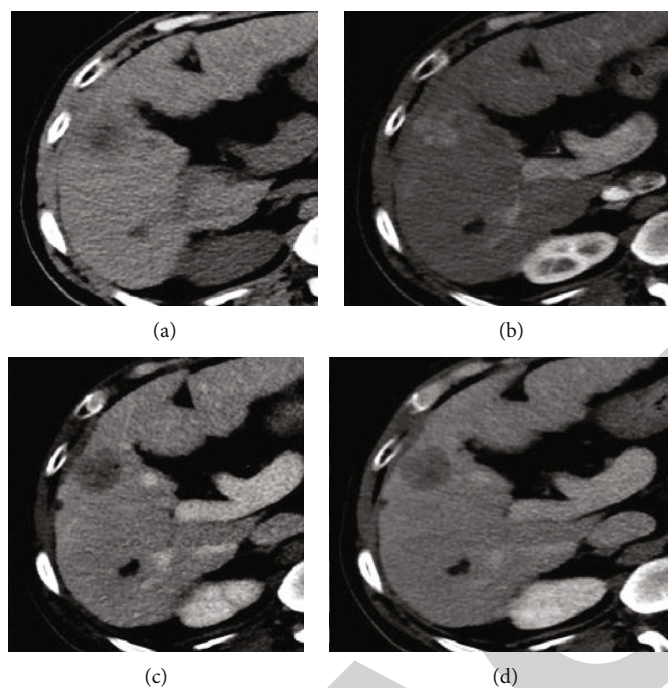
CT image of hepatocellular carcinoma. (a: plain scan period; b: arterial phase; c: portal venous phase; d: delayed phase).
